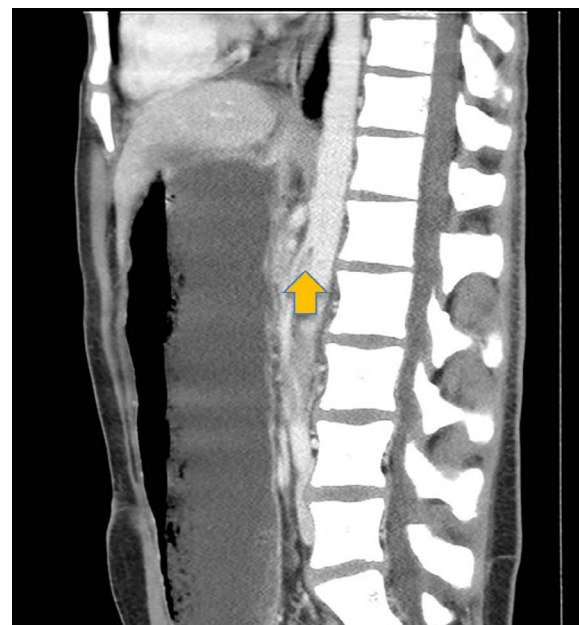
Sagittal view of CT scan noting aortomesenteric distance of 4 mm and aortomesenteric angle of 7 degrees
